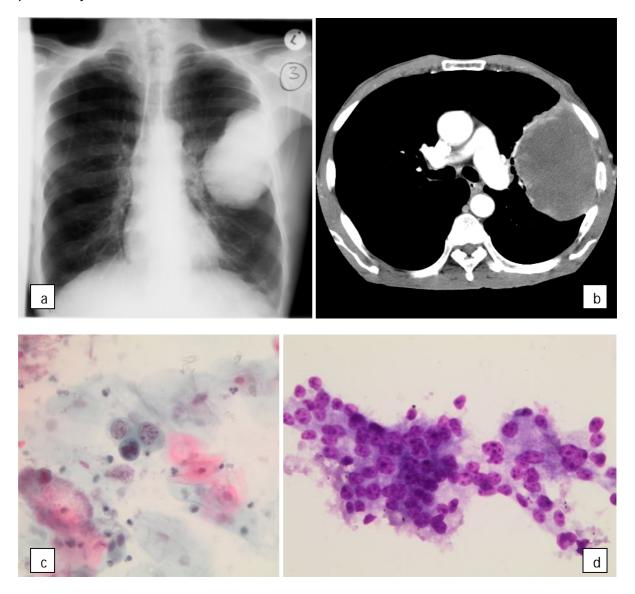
Large mass in the left hemithorax with a broad base of contact with the pleura on chest X-ray (a) and CT (b). Sputum - suspicious for malignancy. Small cells with high N/C ratio and multiple nucleoli (c). TTNA - Adenocarcinoma with delicate cytoplasm and multiple nucleoli (d) MGG.
